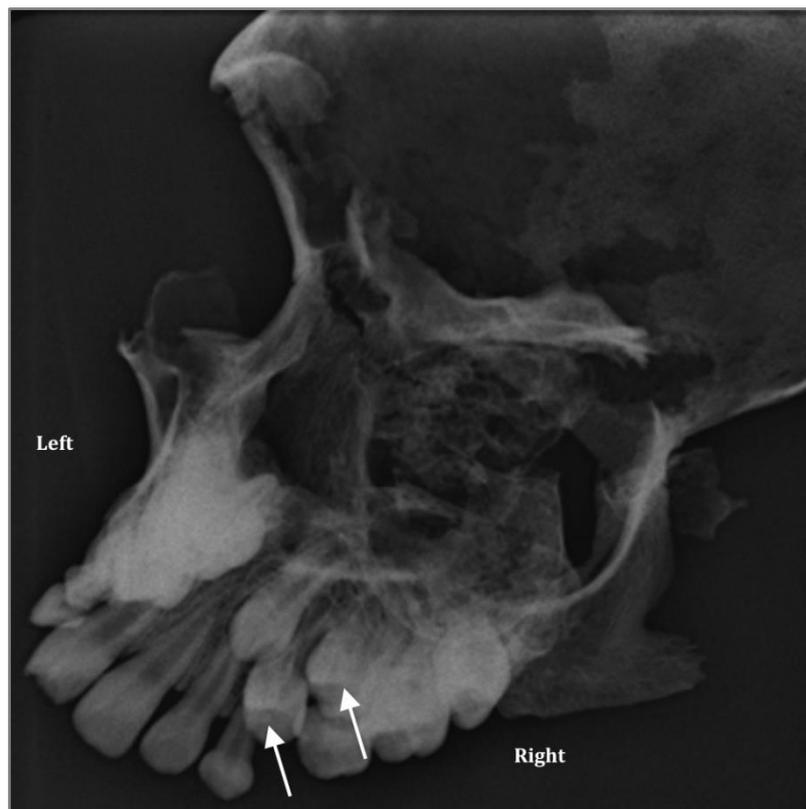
Individual M_450 (X-ray of maxilla): Possible retained deciduous teeth and lack of space for normal dental development on the right maxillary region.
